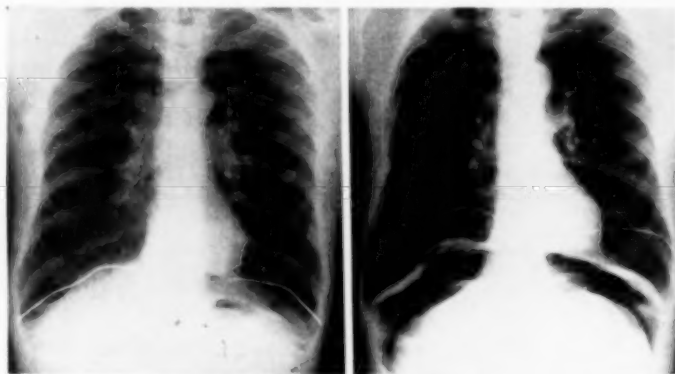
Case 3: From x-ray films showing limits of maximal diaphragm excursion before and after pneumoperitoneum treatment. For a description of technique, see legend, figure 2.
